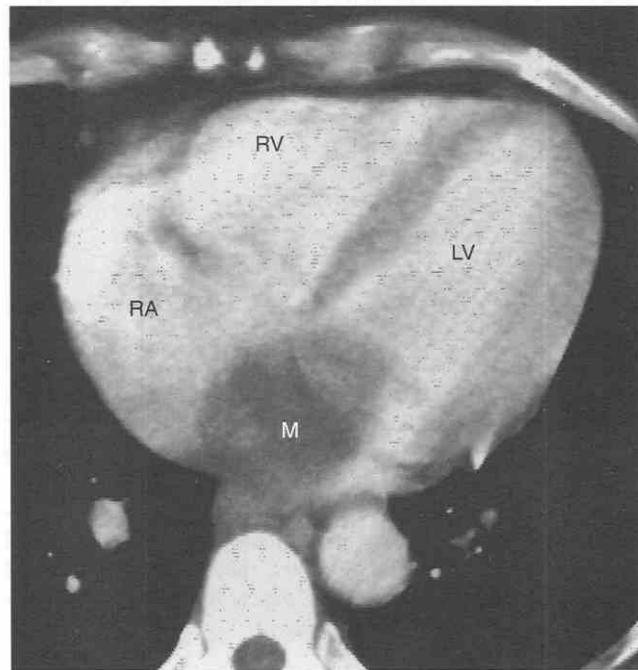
Myxoma. This patient presented with symptoms thought to be secondary to mitral stenosis. Axial CT with intravenous contrast medium shows a large mass (M) nearly filling the left atrium. At surgery, the tumor was found to arise from the interatrial septum. LV, left ventricle; RA, right atrium; RV, right ventricle. (Courtesy of Robert D. Tarver, M.D., Indiana University Medical Center.)
